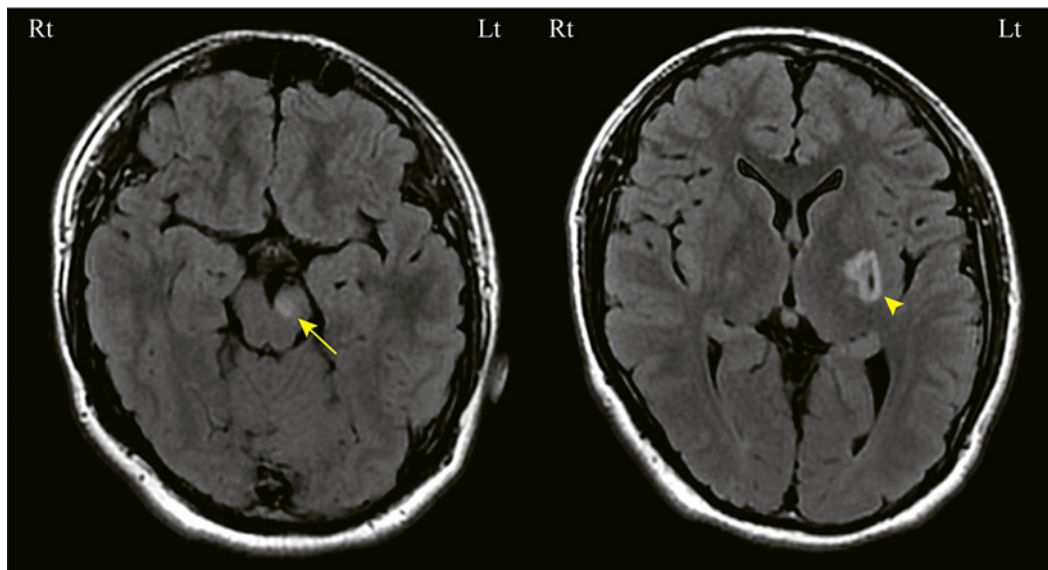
Head magnetic resonance imaging during a close examination for dystonia. White lesions were detected from the left putamen to the cerebral peduncle (arrow, arrowhead, FLAIR image).
